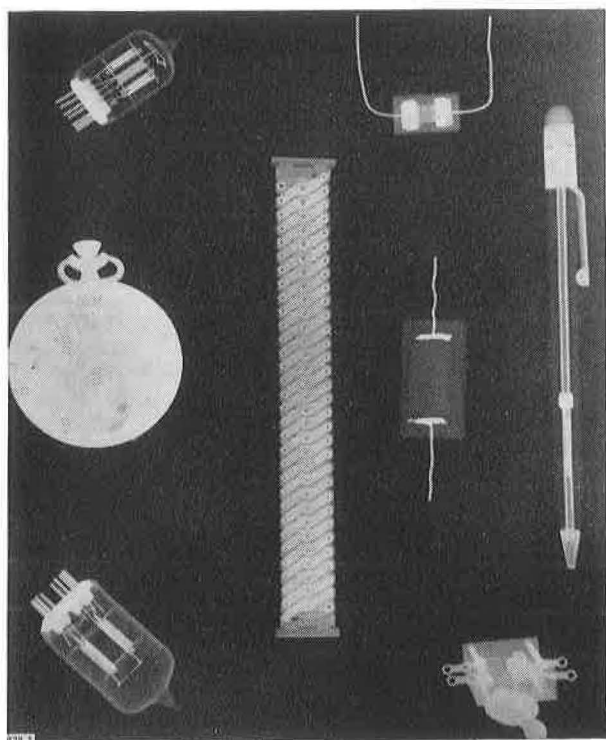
Technical radiograph, 44-hr exposure at 10 in. from a promethium tungstate source
